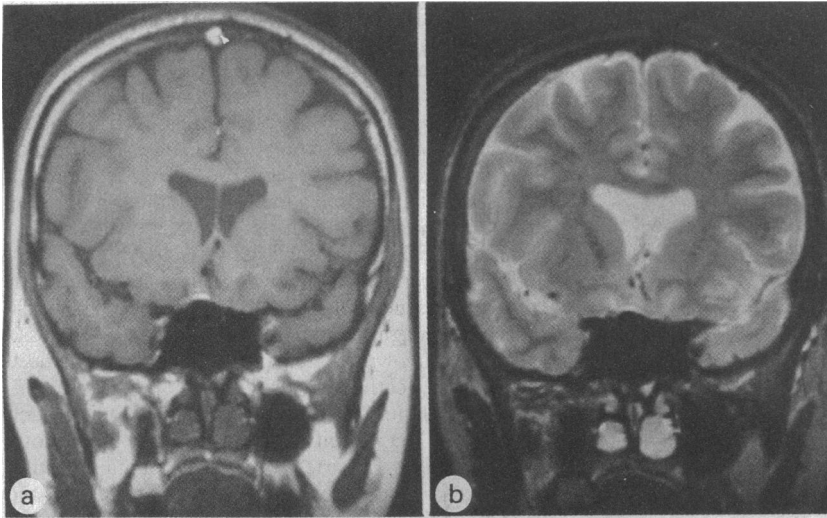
Normal magnetic resonance imaging of head (coronal section through frontal horns of lateral ventricles) showing differences between T1 and T2 weighted images. (a) In the T1 weighted image cerebrospinal fluid shows low signal; grey matter appears grey; white matter appears whiter; and fat, which shows the highest signal intensity, appears white. (b) In the T2 weighted image cerebrospinal fluid in the lateral ventricles and subarachnoid space surrounding the brain is of high signal, grey matter appears whiter than white matter, and fat is of intermediate signal
